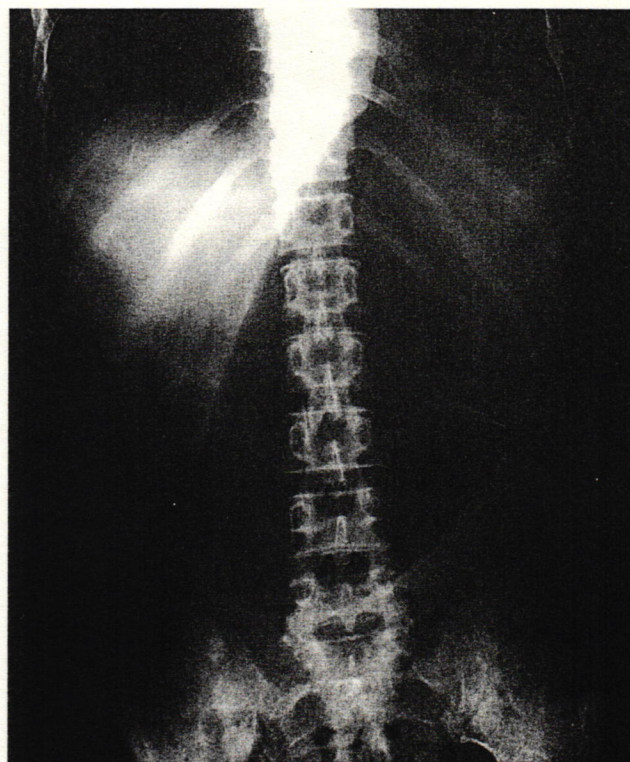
An abdominal radiograph showing a large amount of air in the stomach.
